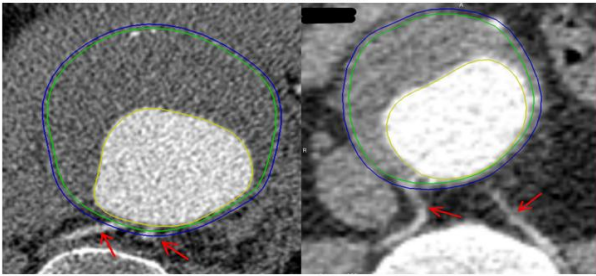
The CT scans of two of reconstructed AAAs in A4Research program. Red arrows indicates lumbar arteries. Outer surface is marked by blue line, wall-ILT interface by green line and lumen by yellow line.
